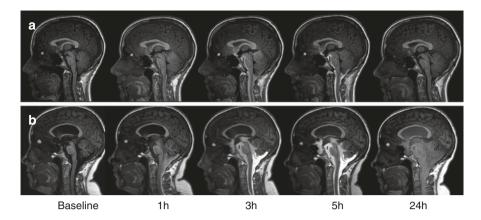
T1 weighted MRI in sagittal plane from MRI at baseline and 1, 3, 5, and 24 h after intrathecal contrast agent administration in (a) a 24-year-old reference individual and (b) a 32-year-old patient with communicating hydrocephalus. The reference individual underwent MRI for suspected CSF leakage but no leakage was found, and symptoms resolved spontaneously within months. The contrast enhancement was visible within the spinal and basal intracranial subarachnoid spaces and with a marked decline after 24 h (a). In the patients with hydrocephalus, contrast enhancement of the subarachnoid and intraventricular spaces was even more evident, with reflux of contrast agent to the third ventricle after 3 h (b). After 24 h, clearance of the contrast agent was delayed in the patient with hydrocephalus (b) as compared to the reference subject (a)
